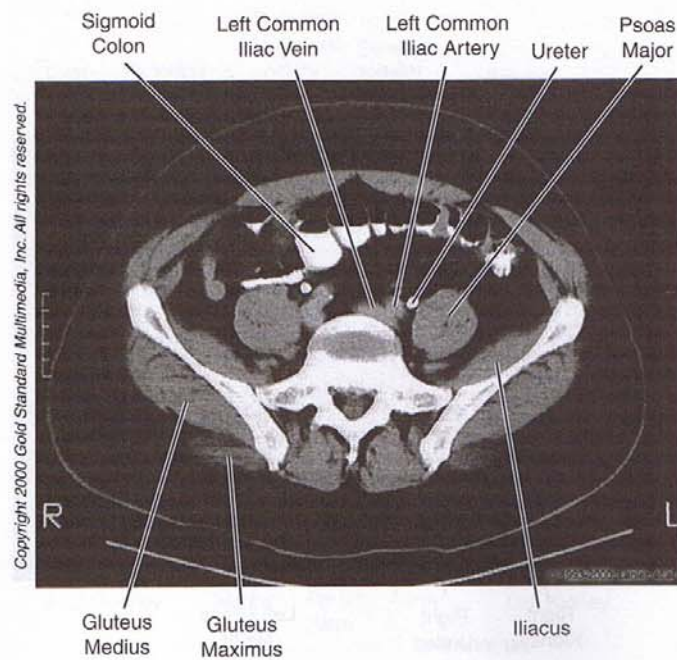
Abdomen: CT, S₁
